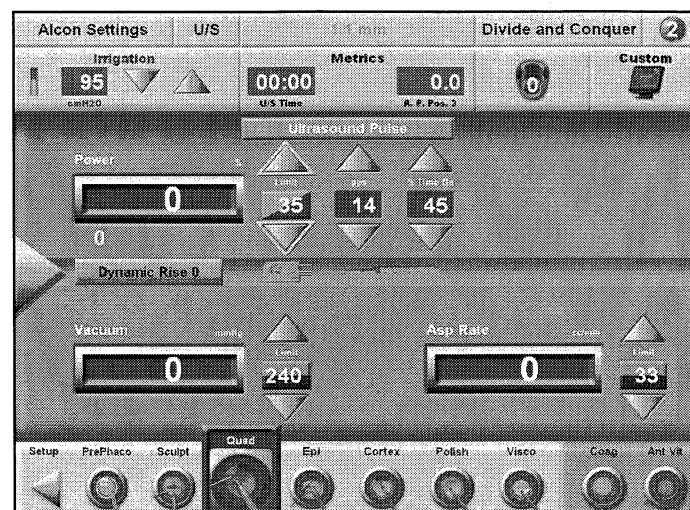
The Ultrasound Pulse Surgery Screen
